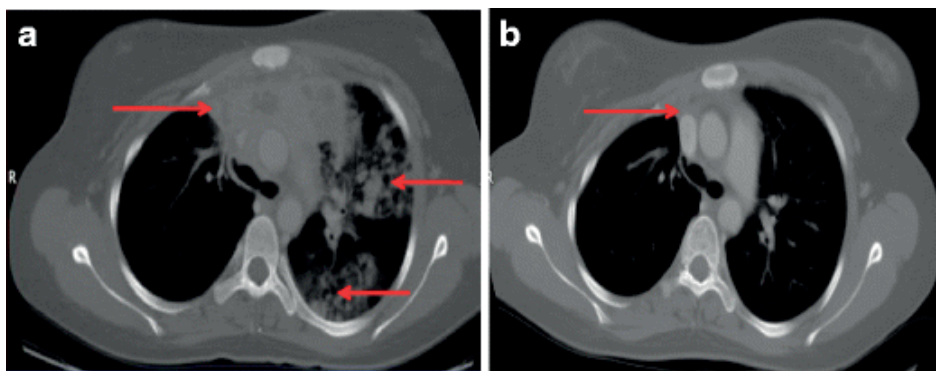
Patient 1. a CT chest showing necrotizing mediastinal lymphadenitis and extensive parenchymal disease due to refractory MAC infection; b After 1 year of treatment with IFN- α , cervical, mediastinal and parenchymal disease had resolved completely.
